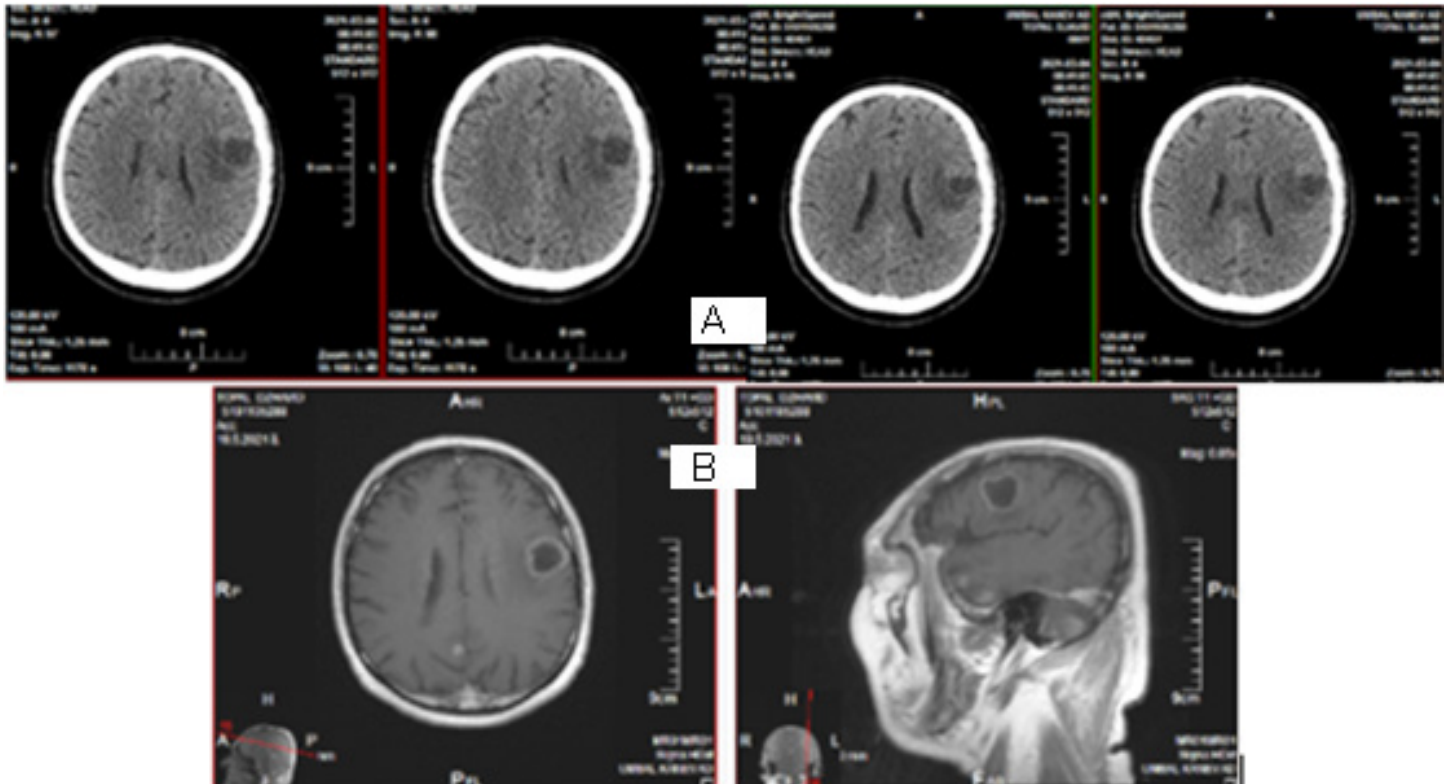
A/B CT and MRT image of the brain metastasis in left brain hemisphere after radiosurgery with 15 Gy.
